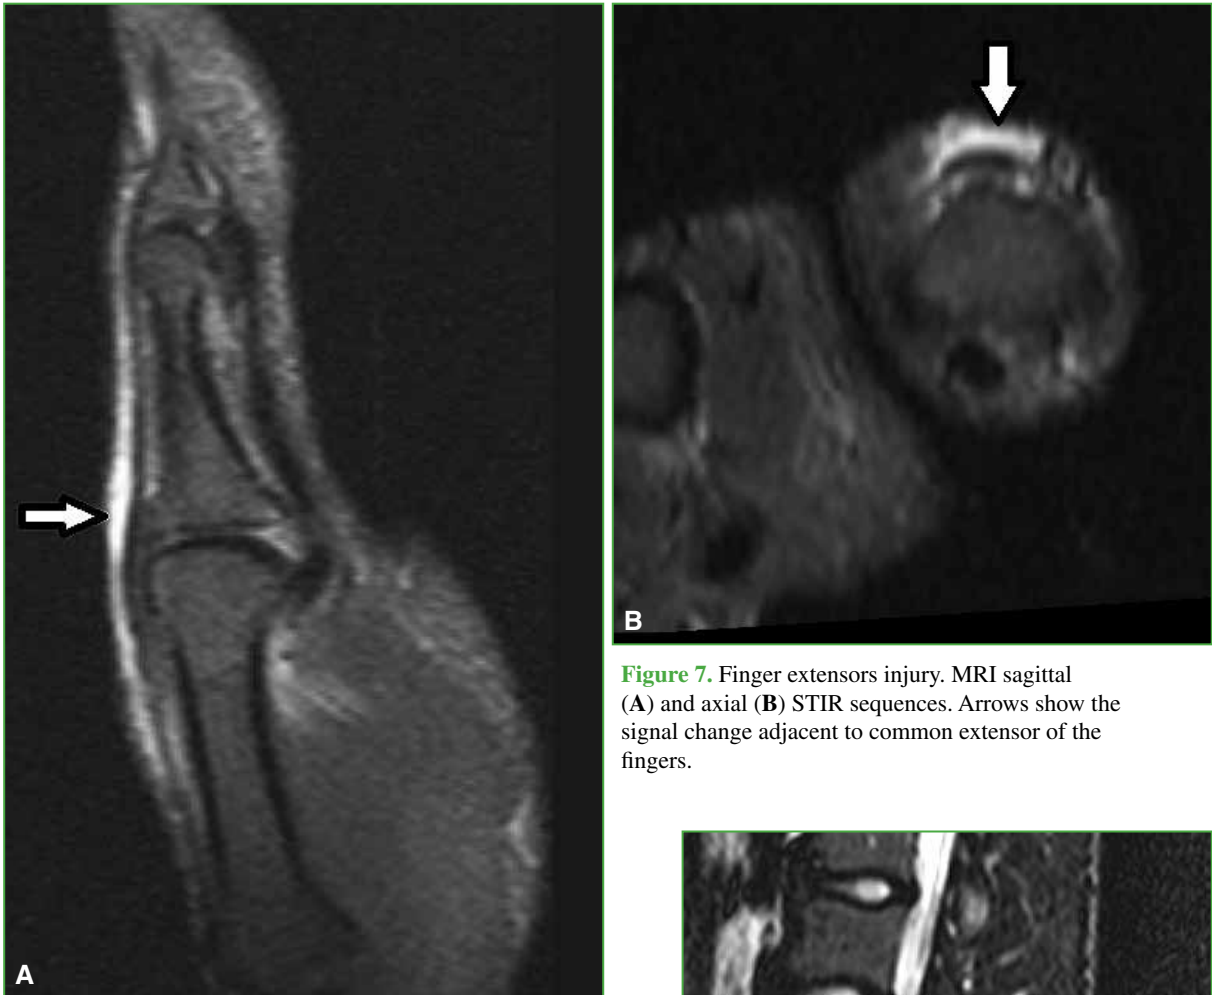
Finger extensors injury. MRI sagittal (A) and axial (B) STIR sequences. Arrows show the signal change adjacent to common extensor of the fingers.
